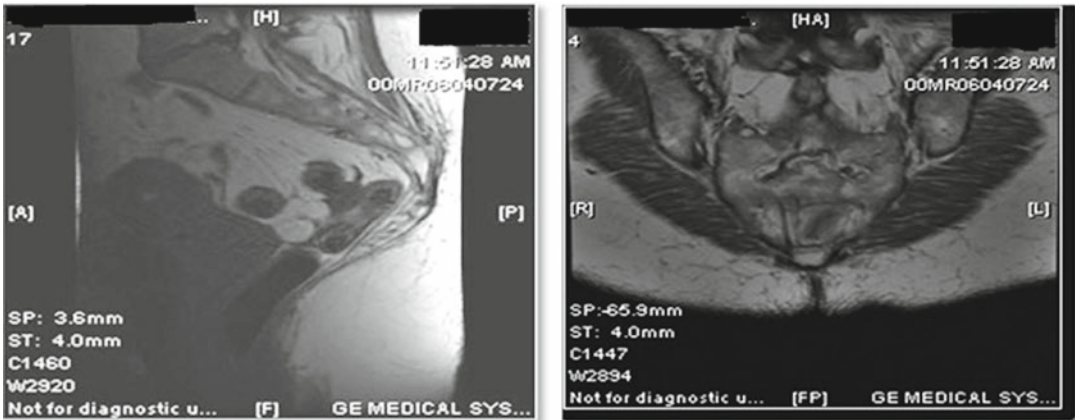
(a, b) An MRI of a patient undergoing preoperative planning for a trans-sacral approach
